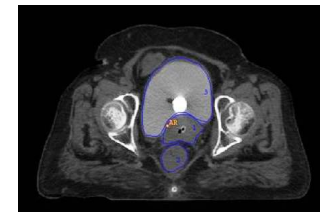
Cross Sectional Image of 3D CT Based Treatment Planning
